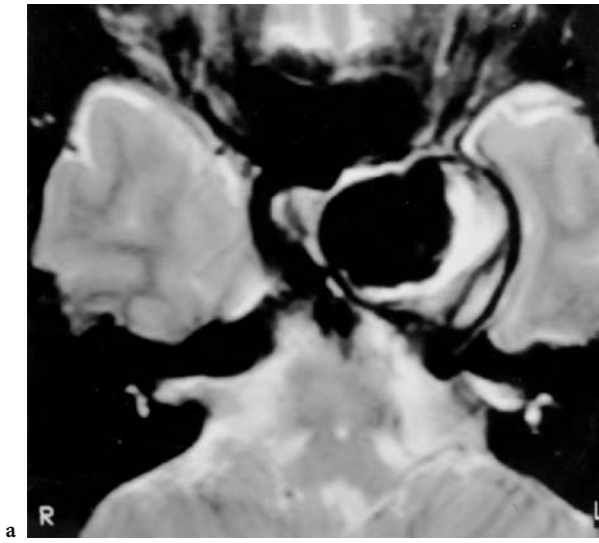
A 16-year-old boy with double vision to the left, headache, and slowly resolving ptosis of the left eye. Diagnosis: intracavernous aneurysm of the left ICA. MRI: a Axial T2-weighted view of the sellar region with excavation of the cavernous sinus by a primarily hypointense (flow void) lesion with hyperintense rim, representing the freshly thrombosed (methemoglobin) periphery of the aneurysm. b Coronal T1-weighted view showing substantial lateral expansion of the aneurysm: Beginning at the wall of the cavernous sinus, the mesial temporal lobe is apparently depressed and dislocated by both the open and the thrombosed part of the aneurysm. c Left paramedian sagittal T1-weighted image demonstrating the inflow zone of the aneurysm, whose proximal part is compressed by the thrombus. Note expansion to the brainstem with compression of N III (*small arrow*) located between the superior cerebellar (flow void below) and PCA (above), and additional compression of the left optic tract (*large arrow*) by distal ICA and proximal ACA. DSA: d Frontal view, early arterial phase where the configuration of the open part is comparable to the coronal MRI of b. e Frontal view, later arterial phase with relatively low opacification of the distal ICA, and bifurcation into the MCA and ACA. f Lateral view, compared with c, demonstrating only the open areas of the aneurysm, while the surrounding structures are not visualized
